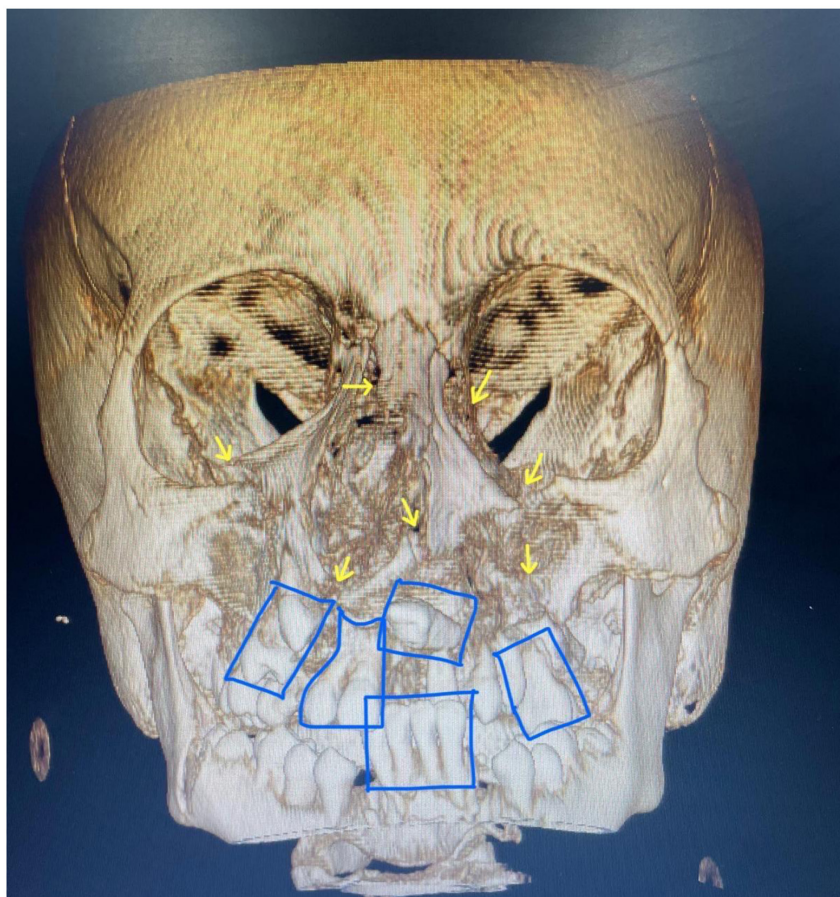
Computed tomography of the face showing multiple fractures in the patient.
